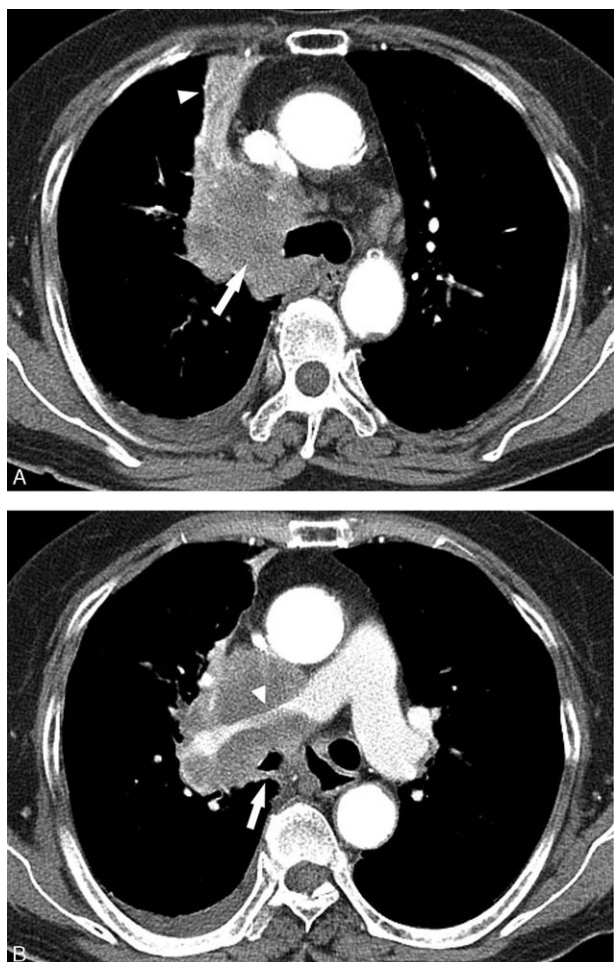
A 79-year-old female with SCLC (Type IIb). Axial CT mediastinal images show a right hilar with ipsilateral mediastinal conglomerate mass. (A) The mass occludes the right upper lobar bronchus (white arrow) and results in atelectasis of the right upper lobe (white arrowhead). (B) Note the encasement of the bronchus intermedius (white arrowhead) and right main pulmonary artery (white arrowhead) by the mass, resulting stenosis. CT=computed tomography, SCLC=small cell lung carcinoma.
